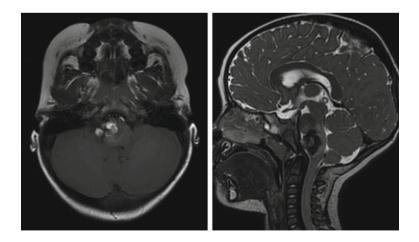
Axial T1 (left) and Sagittal T2 (right) weighted magnetic resonance images showing 2.5 cm pontomedullary cavernous malformation in a two year-old female who presented with left hemiparesis and cranial neuropathies
